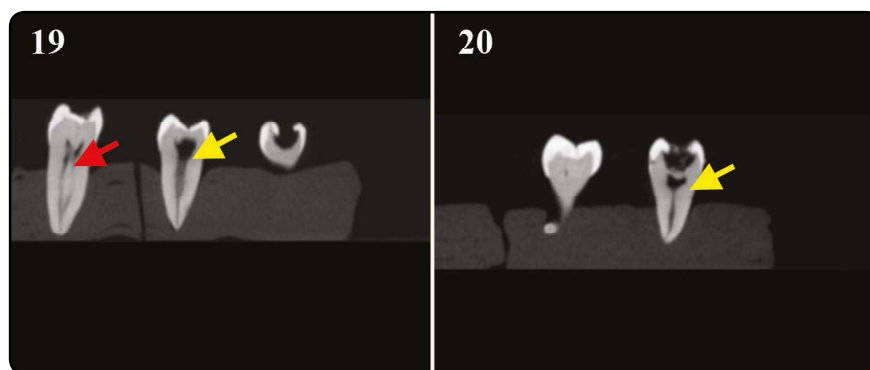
CBCT showing M1 with type I (yellow arrow) and type II (red arrow) distal root canal configuration. Fig. 20. CBCT showing M3 with type I (yellow arrow) distal root canal configuration.
